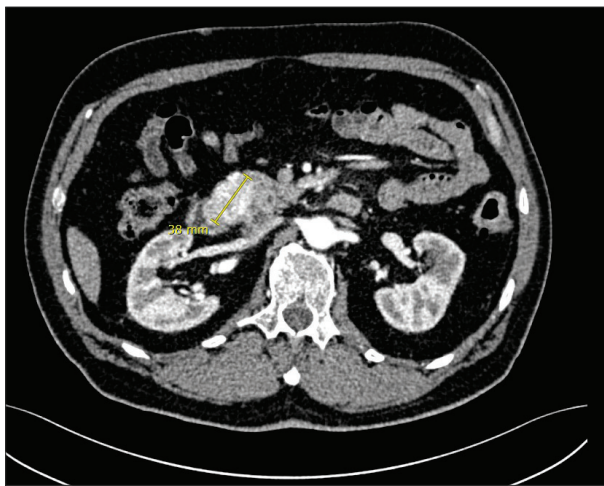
Abdominal computed tomography scan shows the tumor measuring 38 mm with uneven margins and possible infiltration of the pancreas
